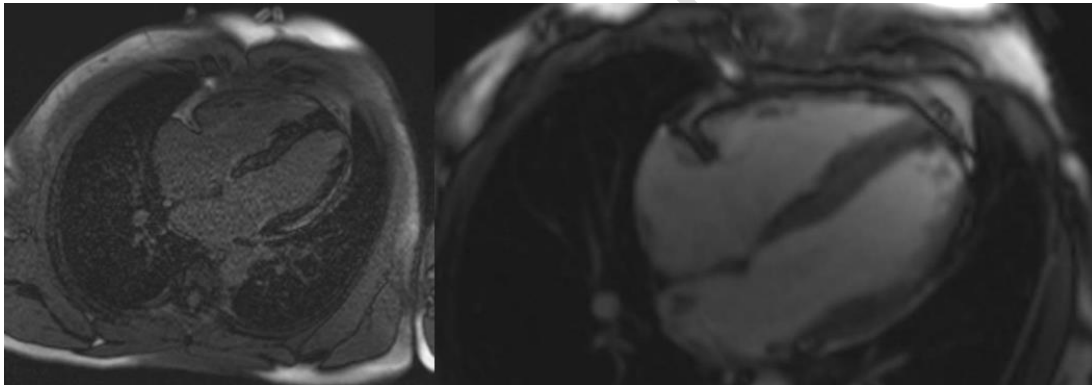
cardiac MRI of the patient showing signs of myocarditis
